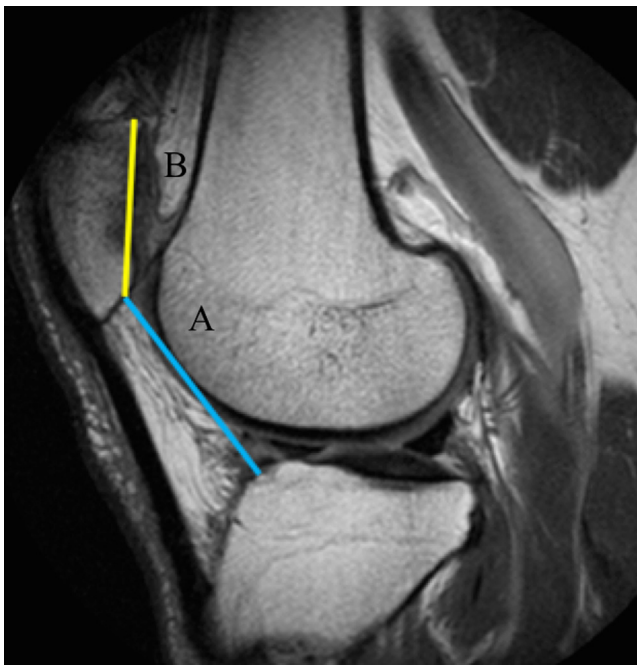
Caton-Deschamps Index (CDI) measurement from sagittal MRI slice with the greatest length of the patella. The CDI equals the distance from the distal aspect of the patellar articular cartilage to the anterosuperior corner of the tibial joint surface (blue line in A), divided by the length of the cartilaginous articular surface (yellow line in B).
